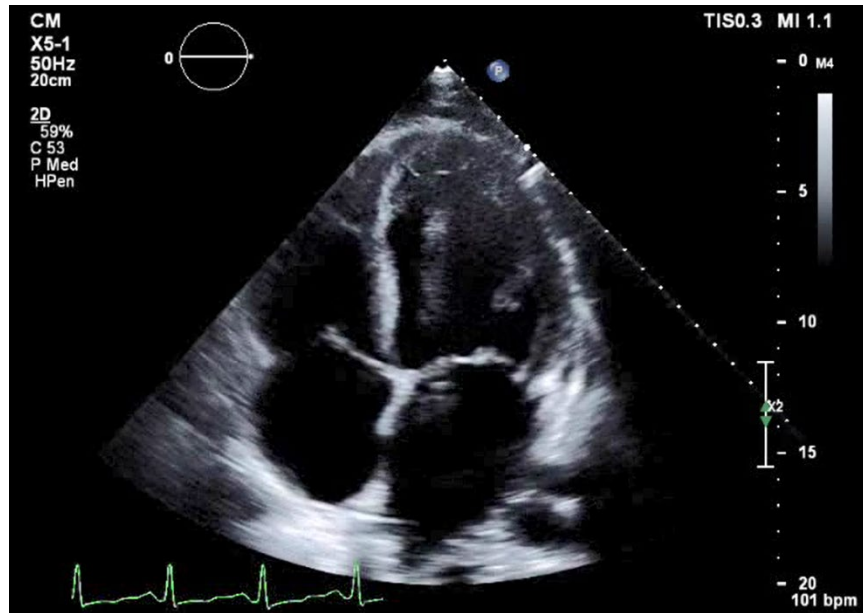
2d-Transthoracic Echocardiography: A left ventricular apical thrombus can be seen on 2d-TTE in the 4-chamber apical view.
